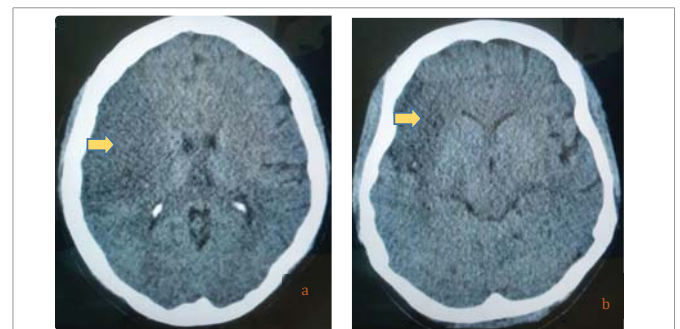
Non-contrast CT showed territorial infarction in the right middle cerebral artery territory from the insular/perisylvian to the fronto parietal cortex involving mainly the superior division of the MCA but sparing the lenticulostriate territory.
